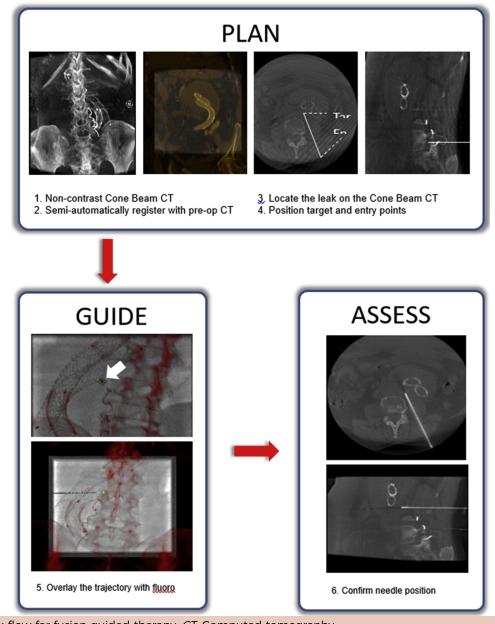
Work flow for fusion-guided therapy. CT, Computed tomography.
